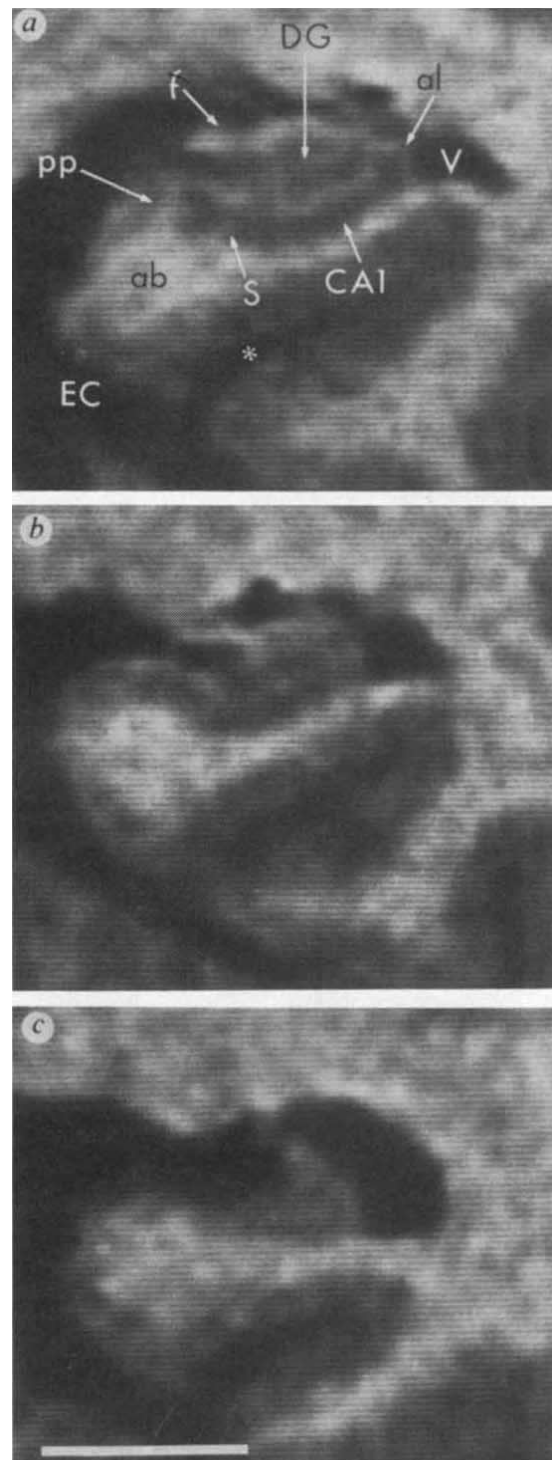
Higher magnification magnetic resonance images than those shown in Fig. 1 of the left hippocampal formation. a, T1-weighted image (TE = 400 ms, TR = 20 ms) of a 5-mm thick section through the hippocampal formation of a 24-year-old normal subject. It is possible to distinguish the angular bundle (ab), the perforant path (pp), the alveus (al), the molecular layer of the dentate gyrus (DG), and the fimbria (f). The pyramidal cell layer of the subiculum (S) and the CA1 field of the hippocampus (which are ~1.5-mm thick in the coronal plane at this level) can also be seen. The entorhinal cortex (EC) lies just ventral to the angular bundle. The region of high signal intensity superficial to the pyramidal cell layer marks the stratum lacunosum-moleculare, in which the perforant path projects to the hippocampus and dentate gyrus. The temporal horn of the lateral ventricle (V) lies just lateral and dorsal to the hippocampus, and the asterisk marks the position of the collateral sulcus. b, Hippocampal formation of control subject C1 at the same level seen in Fig. 2. Whereas this image is not as distinct as the one from the younger subject, most of the anatomical features identified in that image can also be distinguished here. c, Hippocampal formation of amnesic patient L.M. at the same level as in Fig. 1. In contrast to the images in a and b, the fimbria is not distinct in this image, and it is difficult to determine the boundary of the pyramidal cell layer in the subiculum or hippocampus. In addition, there is marked reduction of the size of the dentate gyrus, hippocampus, and subiculum. The calibration bar represents 1 cm in all three panels.
